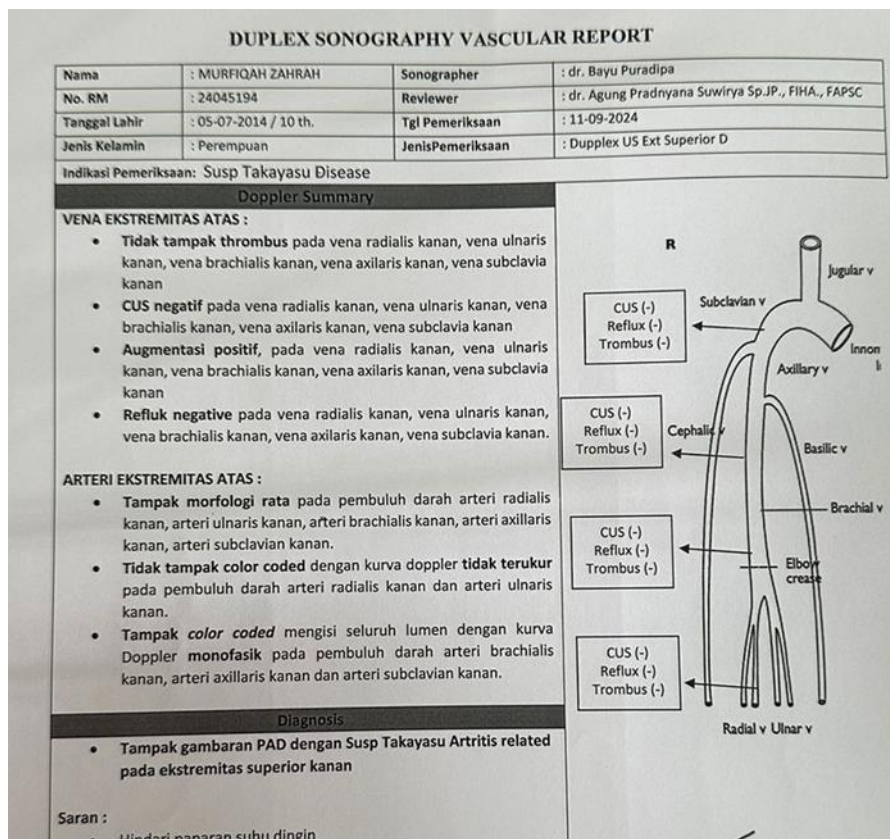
Results of Duplex Sonography Vascular Right Superior Extremita
